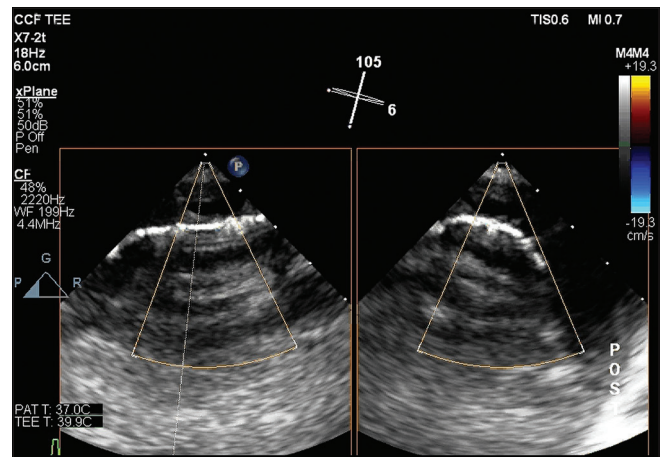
Transesophageal echocardiogram (TEE), the short axis of the descending aorta and aortic graft, using Color Flow Doppler and Multiplane. Demonstrates poor definition of flow within the graft material. Inadequate demarcation of graft lumen and position of graft material within the descending aorta. Poor visualization of anatomical structures
